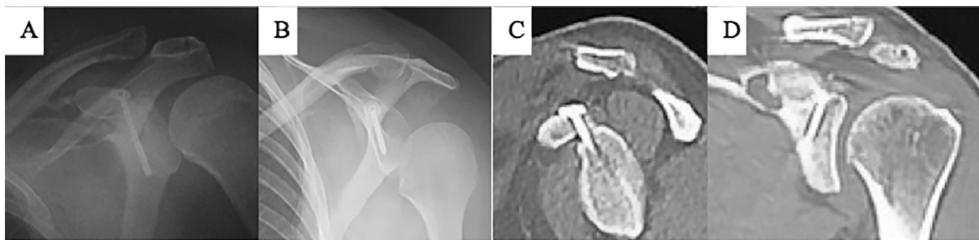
A, B, C, D: (A) postoperative X ray at day two showing reduction of AC joint and bony tunnels for anatomic restoration of AC ligaments, (B) postoperative X ray at tenth week showing maintained position of AC joint although in (C) CT scan sagittal cut showing non anatomical reduction of CP, (D) CT scan coronal cuts showing partial union of CP comminuted base fracture at tenth week.
